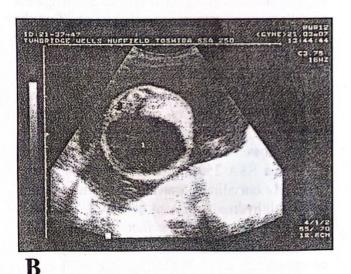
Longitudinal and transverse sonograms of the foetal abdomen showing the cystic dilatation in the abdomen (1) and a smaller cystic dilatation above the diaphragm posteriorly (2).
